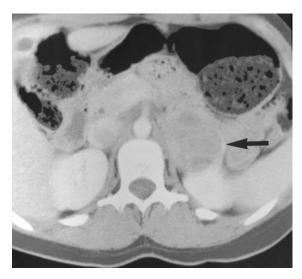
Adrenal computed tomographic scan showing a large left adrenal pheochromocytoma in a patient with multiple endocrine neoplasia type IIA.
